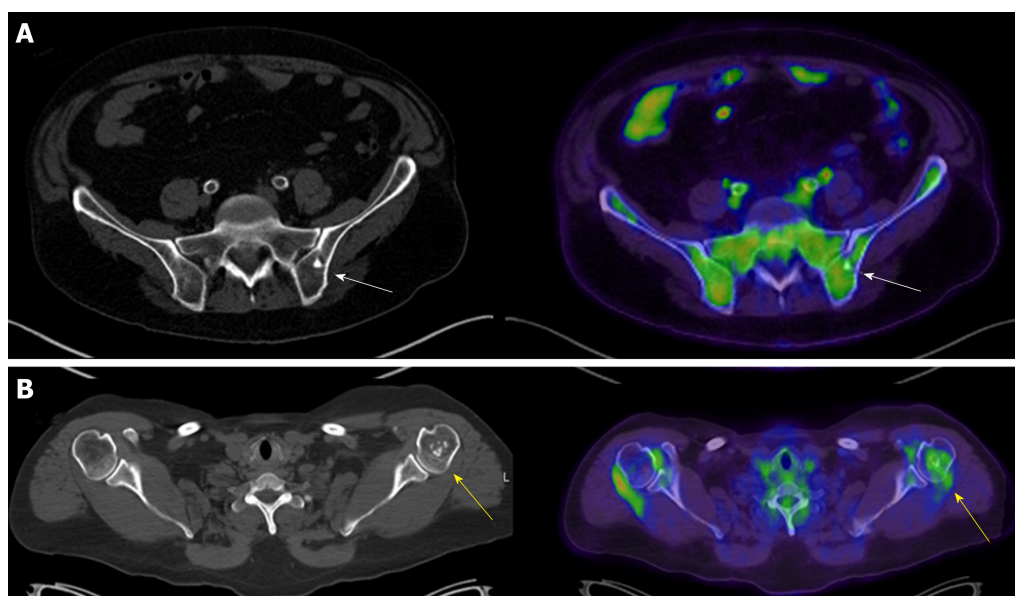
Axial computed tomography and axial fused positron emission tomography/computed tomography of two patients. A: Axial computed tomography (CT) and axial fused positron emission tomography (PET)/CT of the pelvis in a 76-year-old male with a history of a solitary pulmonary nodule and a bone island in his left ilium (arrows); B: Axial CT and axial fused PET/CT of the chest in a 52-year-old female with a history of melanoma and an enchondroma in the left proximal humerus (arrows) (maximum standardized uptake value 2.33).
